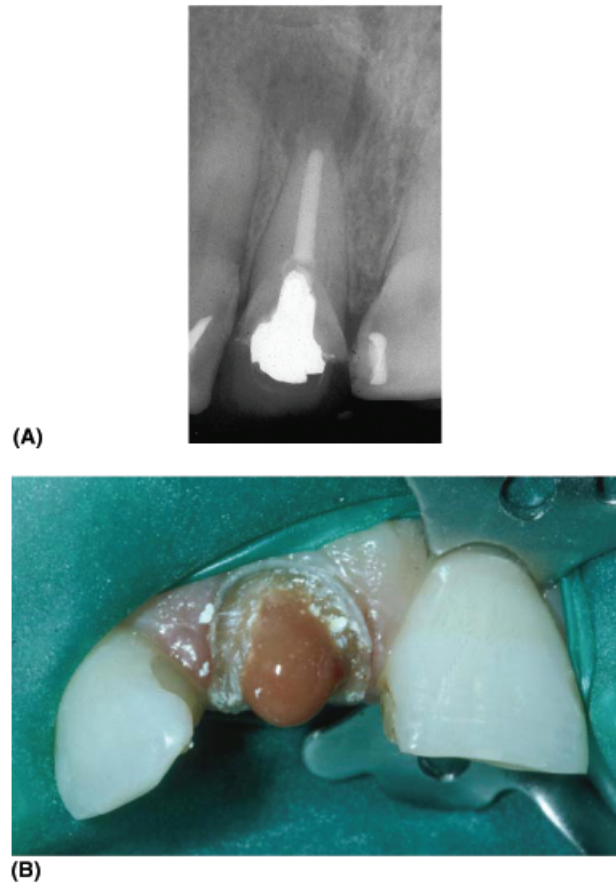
The upper right central incisor had an infected root canal system and a secondary acute apical abscess as a result of breakdown of the crown restoration. The patient presented with extreme tenderness to percussion and pressure on the tooth as well as systemic signs of fever and malaise. (A) The pre-operative periapical radiograph showed a periapical radiolucent area, a previous root filling, a short post and a crown. (B) Drainage was readily established via the canal once the restoration and root filling were removed.
